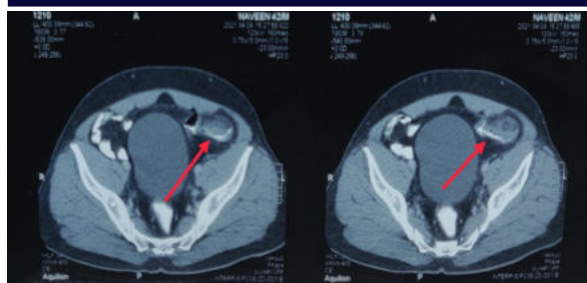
CT axial view showing peritoneal thickening and pericolic fat strandings.
